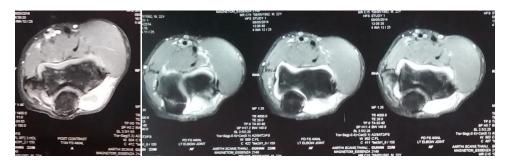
MRI of the patient shows transverse sections of the elbow with synovial reactions in the posterolateral aspect one lateral side of the olecranon.
